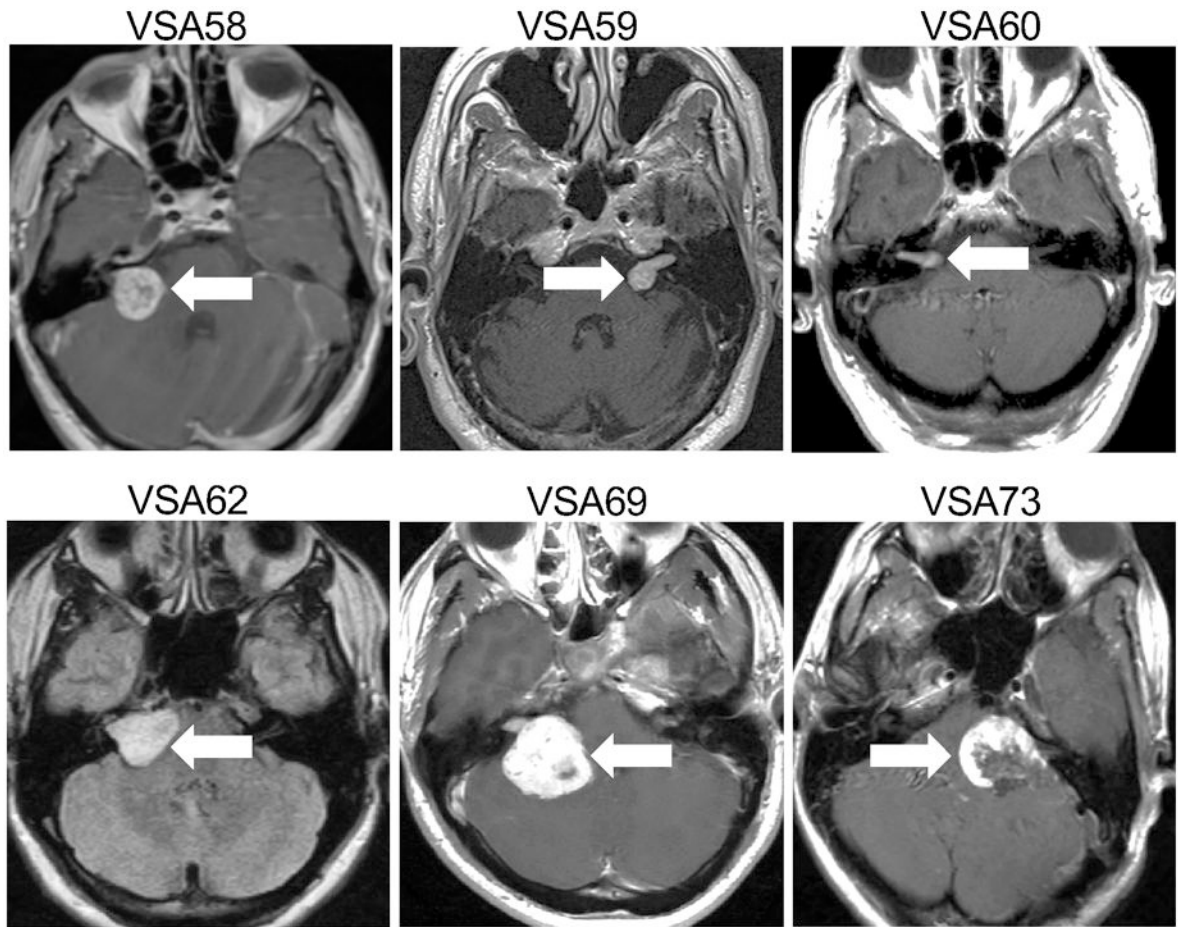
Magnetic Resonance Imaging (MRI) of Vestibular Schwannoma (VS).
